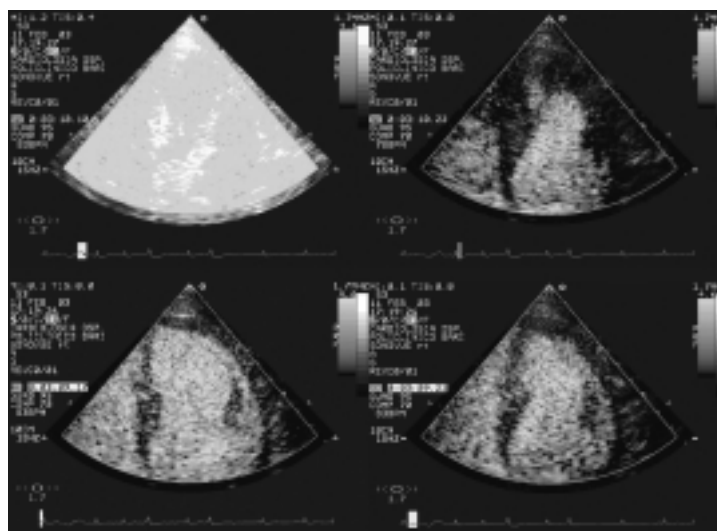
Images of the power modulation method in real time with second-generation contrast (SonoVue, Bracco) destruction and refilling. It is possible to see (upper left) the contrast destruction frame (flash at high ultrasound intensity), followed by a wash out frame at 1 s (upper right), and by a slow refilling at 4 s (lower left) and at 9 s (lower right), difficult to see with the visual color analysis.
